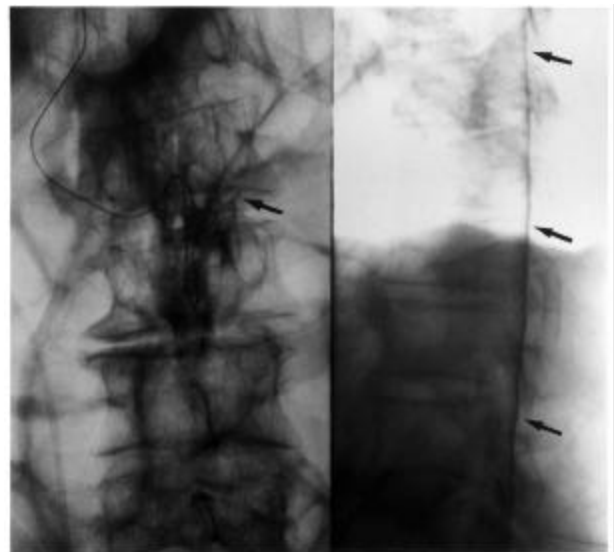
FIGURE Radiographs after the injection of 3 ml contrast medium via the epidural catheter.
